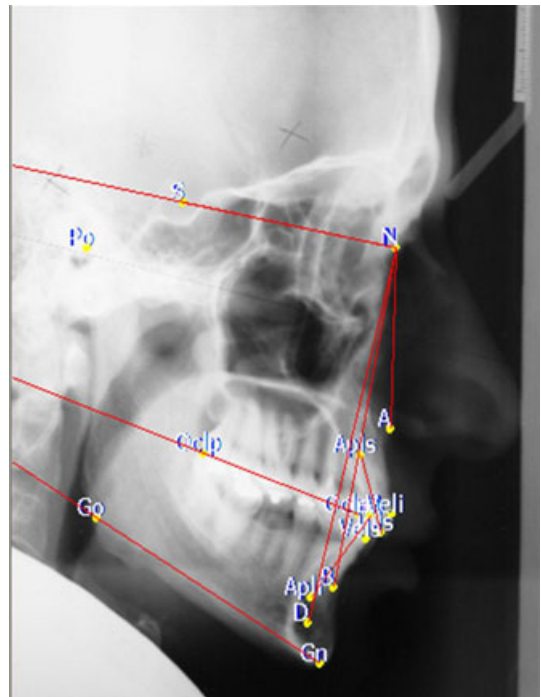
Lateral X-ray image with erroneous positioning of the head in a post-rotated way.
